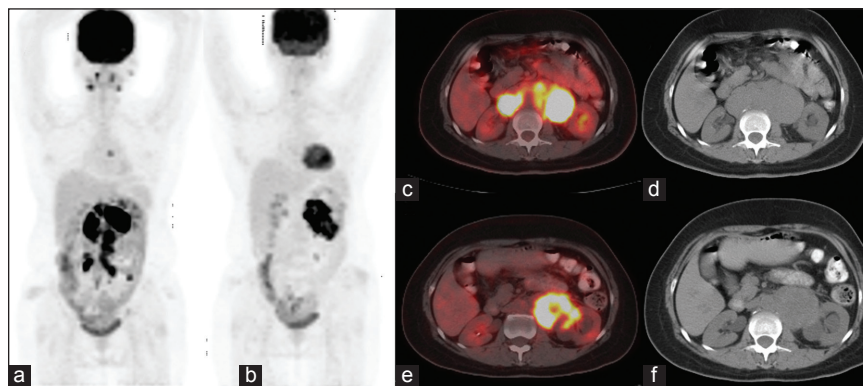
Maximum intensity projection (MIP) image (a) of patient diffuse large B cell lymphoma involving lymph nodes in retroperitoneum. MIP image (b) of the same patient show persistent disease in the abdomen after six cycles of chemotherapy. Also transaxial positron emission tomography/computed tomography (CT) and CT images of pre and post therapy scans respectively (c-f) show persistent fluoro-deoxy-glucose (FDG) uptake in mass which has regressed by less than 50% of sum product diameter (SPD) when compared to baseline scan. Accordingly this patient falls into stable disease category. This image shows stable disease category according to International Harmonization Project (IHP) criteria. According to IHP criteria stable disease is defined as persistently FDG avid disease with less than 50% reduction in SPD of involved lymph nodal masses
